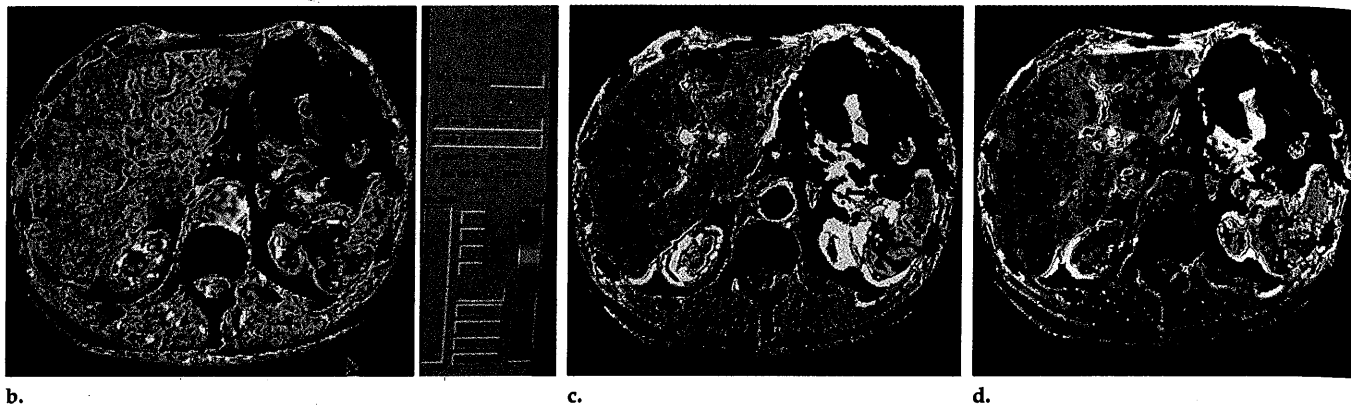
Images of normal liver. (a) Unenhanced CT scan, (b) HPI image, (c) arterial perfusion image, and (d) portal perfusion image.
